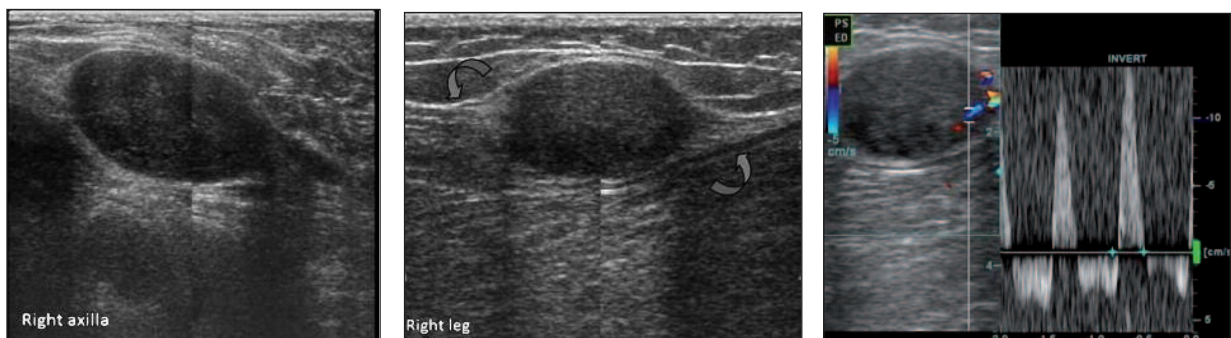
Ultrasonographic (US) images of the right axillary mass (A), right leg mass (B) and Doppler US (C) demonstrating fusiform hypoechoic masses in continuity with ‘cord-like’ structures (curved blue arrows) and to-and-fro arterial Doppler flow patterns.
